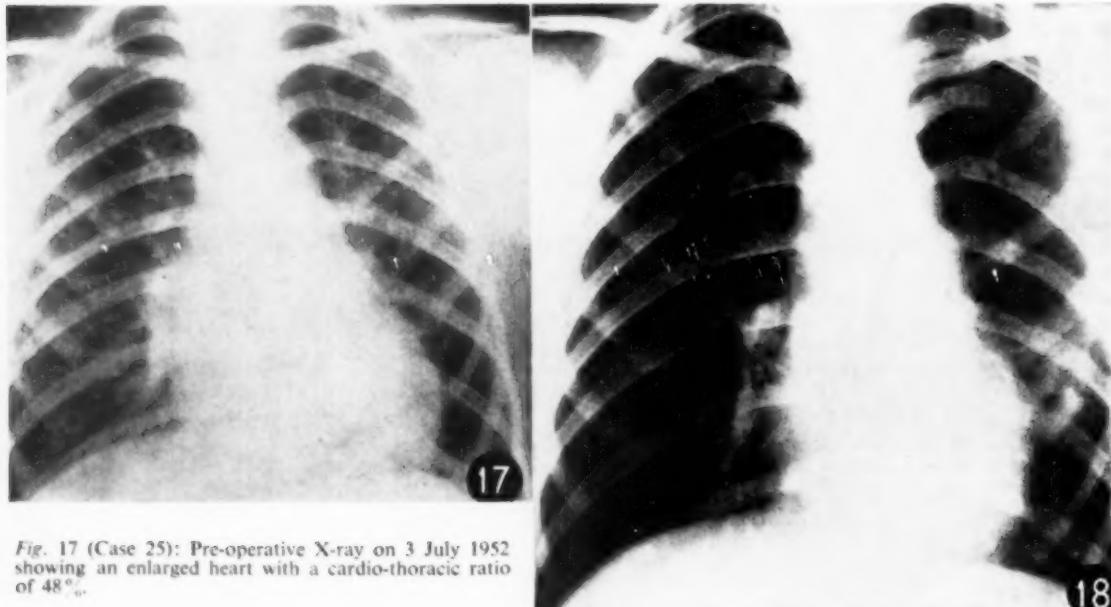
(Case 25): Pre-operative X-ray on 3 July 1952 showing an enlarged heart with a cardio-thoracic ratio of 48%.
